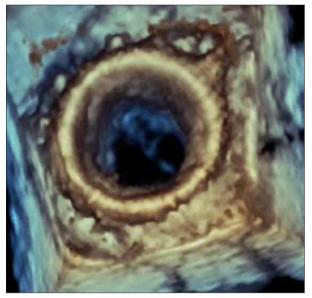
Three-dimensional image of bioprosthetic mitral valve on post-deployment transesophageal echocardiogram: Surgeon's view showing successful placement of the new bioprosthetic mitral valve with full leaflet opening and improved valve area, as compared with Figure 2.
